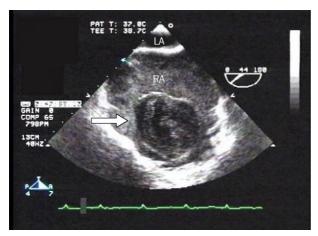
Transoesophageal echocardiogram showing a right atrial clot
